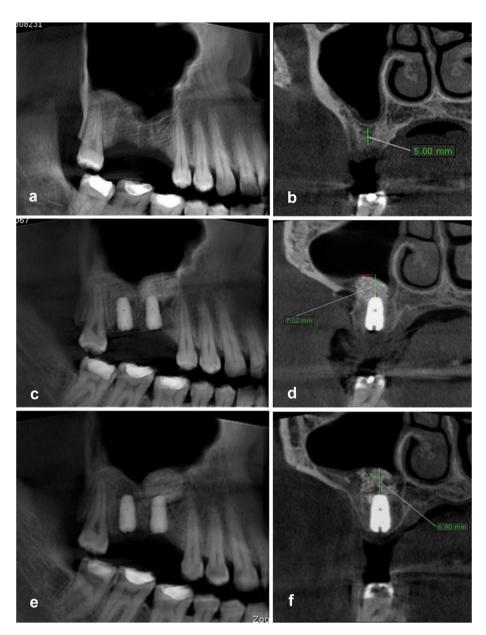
CBCT of patient II. (a) Panoramic view at  $T_x$ . (b) Cross-sectional view at  $T_x$  showing RBH of intended implant site. (c) Panoramic view at  $T_0$ . (d) Cross-sectional view at  $T_0$  showing ABH. (e) Panoramic view at  $T_6$ . (f) Cross-sectional view at  $T_6$  showing ABH. ABH, apical bone height; CBCT, cone-beam computed tomography; RBH, residual bone height.
